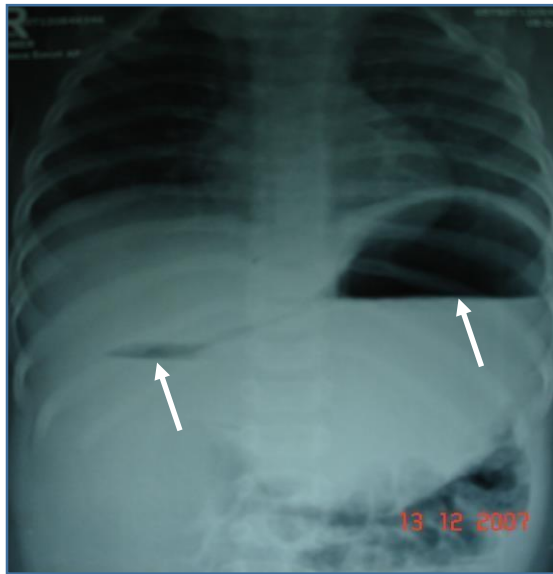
Plain abdominal x-ray shows air in the stomach and first part duodenum "double bubble sign"
